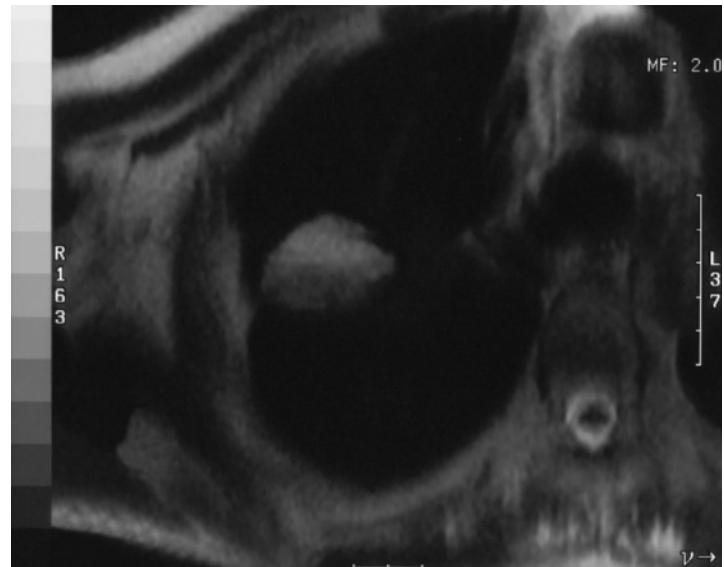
T2-weighted image of massive fibrosis with dust deposit. On T2-weighted images the dust deposit appears unchanged as a signal void, while the mucus fluid above it now appears hyperintense.
